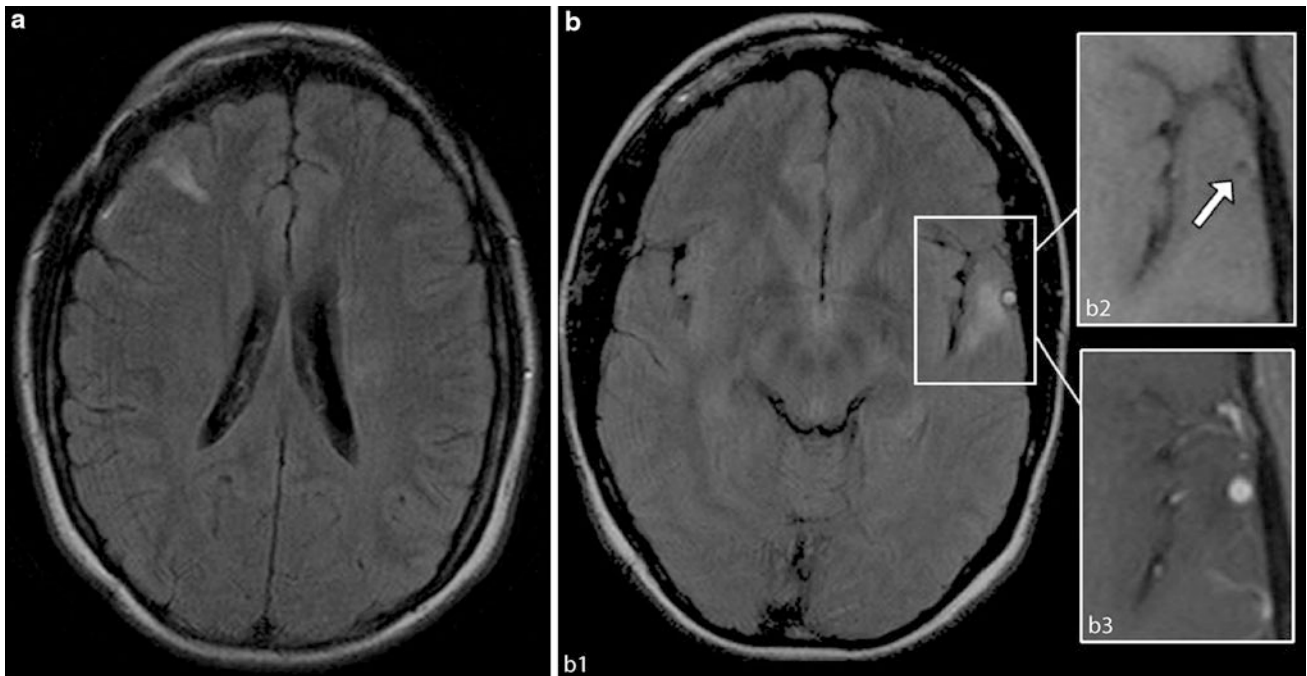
Cerebral arteriopathy in scleroderma. A 32-year-old woman with linear scleroderma “en coup de sabre.” Focal epilepsy starting five years ago was the first sign of cerebral affection. a Axial FLAIR-weighted image. b Axial FLAIR-weighted images (b1). Detail images of axial T1-weighted images of the left anterior temporal pole before (b2) and after contrast administration (b3). Right frontal (a) and left temporopolar (b1) cortical and subcortical white matter hyperintensities.
